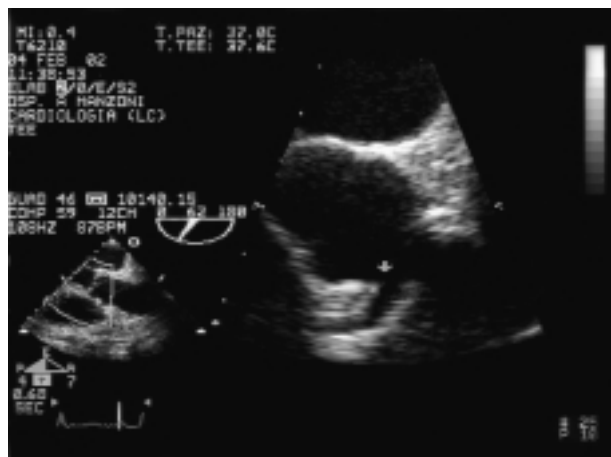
Modified transesophageal short-axis view of the aortic root.
